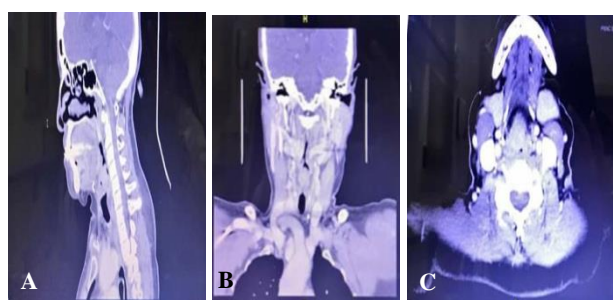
CT scan of the head and neck figures.
